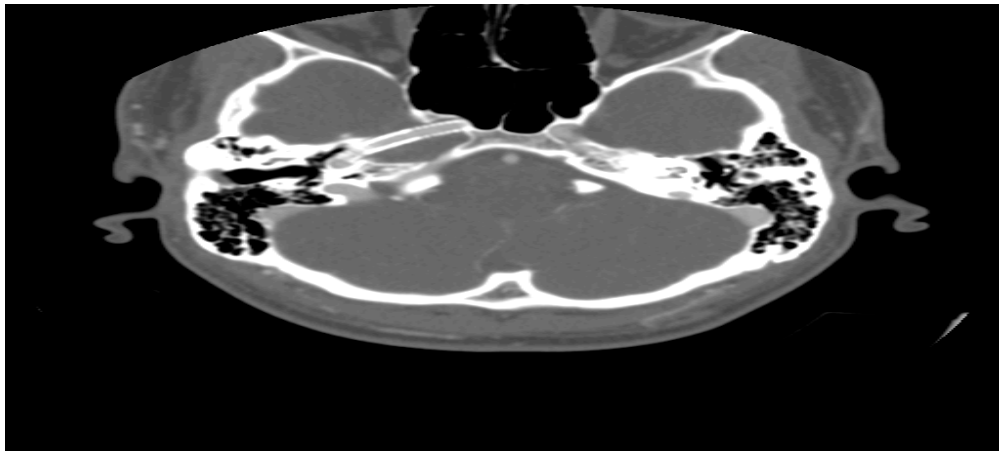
CTA head, 2 years post-procedure
